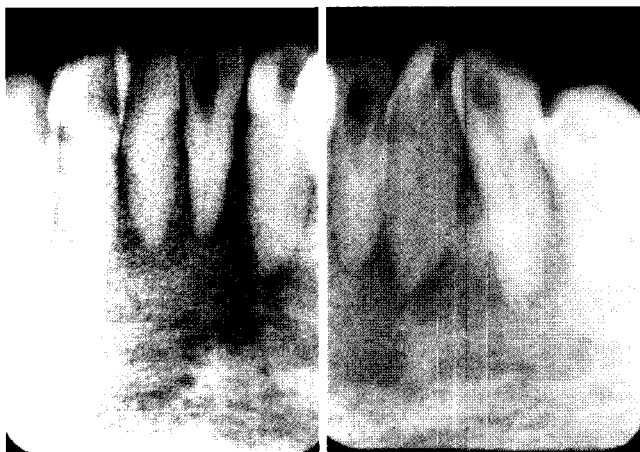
Periapical radiographs showing loss of alveolar lamina dura.
